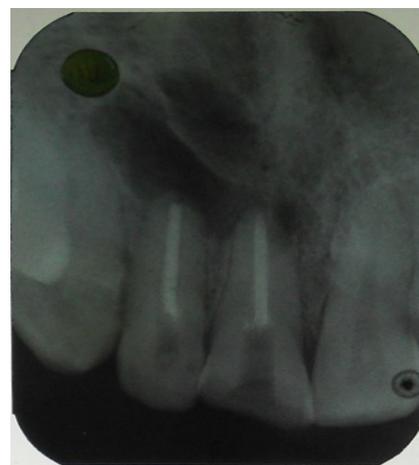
showing periapical radiolucency.
